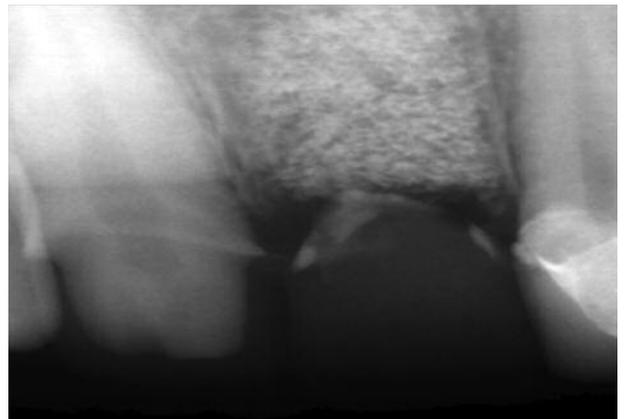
Periapical radiograph showing the resorbed apex of tooth 21.*
